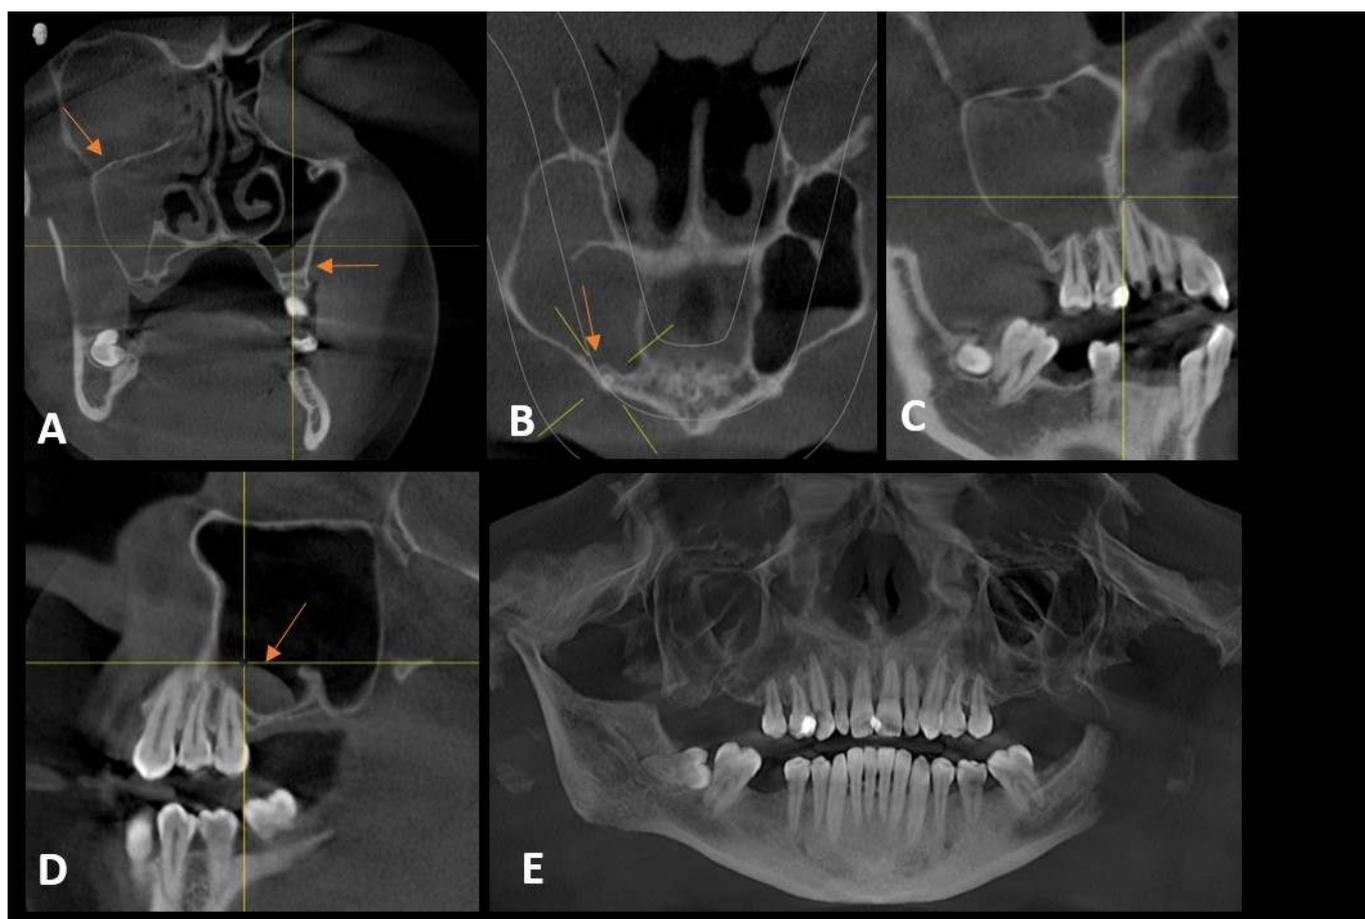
CBCT images showing maxillary sinuses.
